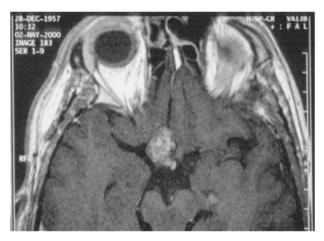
MRI scan showing the lesion in the region of the optic chiasm.
